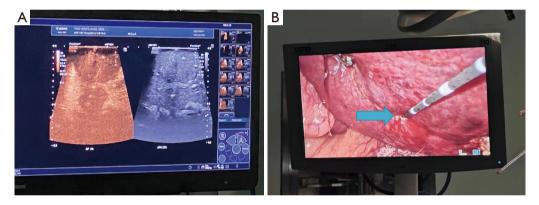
Intraoperative endoscopic ultrasound-guided microwave ablation of liver metastases. (A) Intraoperative ultrasound location and ablation of metastases; (B) laparoscopic ablation of metastases. The blue arrow means the location of liver metastases.
